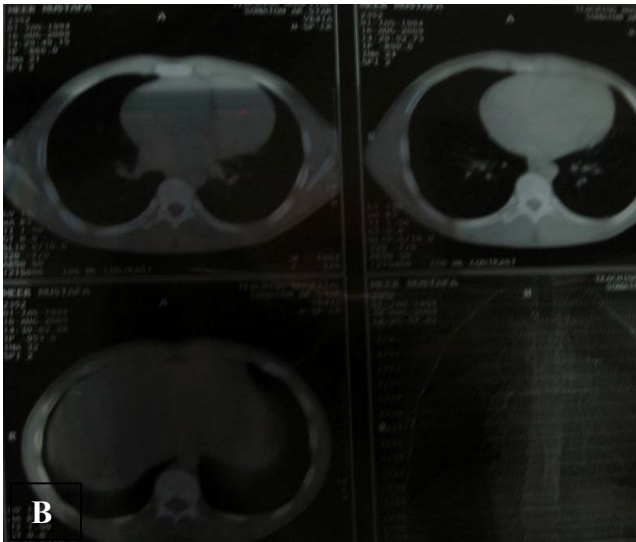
A and B. Chest CT suggested left atrial appendage aneurysm
